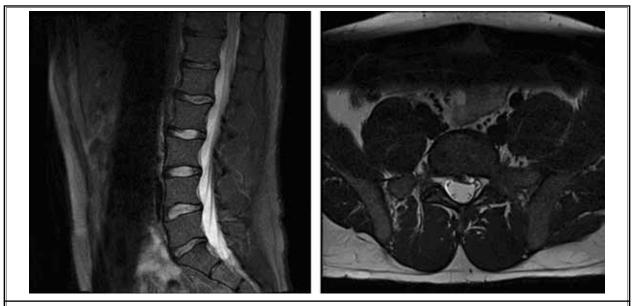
Initial T2 weighted lumbar MRI without contrast taken 12 months before initial consultation exhibiting L5-S1 central disc extrusion impinging on the left S1 nerve root.
